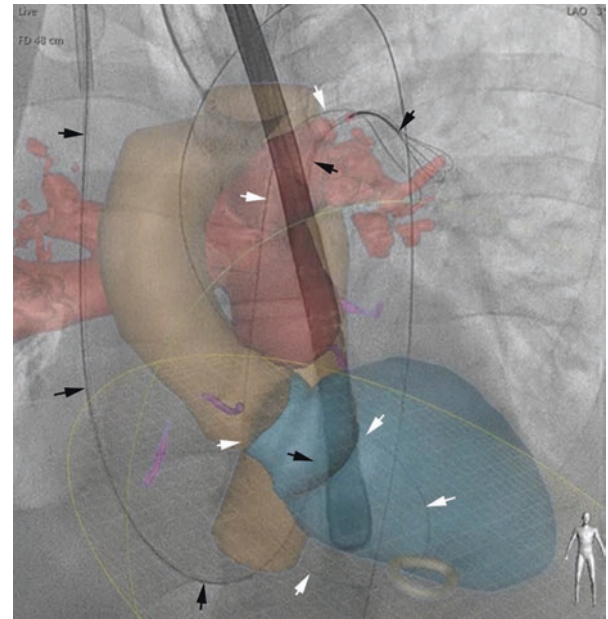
CTA-fluoroscopy fusion—creating arterial-venous (AV) rail. An AV rail is created to support the delivery of device. The left ventricle is seen in blue, aorta in orange, and pulmonary arterial system in red color. The retrograde guidewire (white arrows) crossing the VSD is advanced and positioned in the left pulmonary artery. Then, a 6F JR4 guide catheter with an 18 × 30 mm Ensnare system (black arrows) is advanced through the right internal jugular vein. The retrograde guidewire is snared and externalized creating an AV rail
